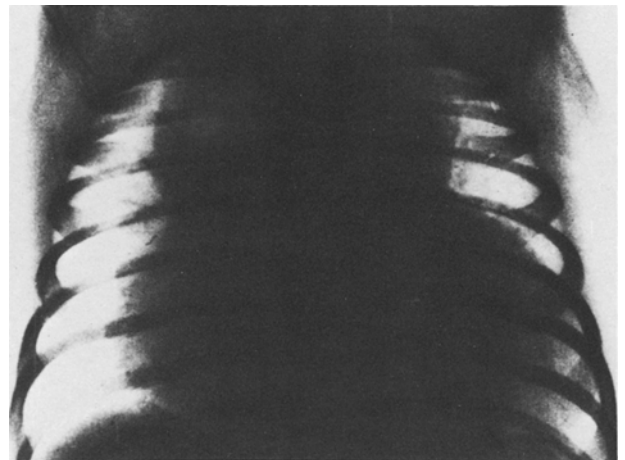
Preoperative chest x-ray film showing marked cardiomegaly.
